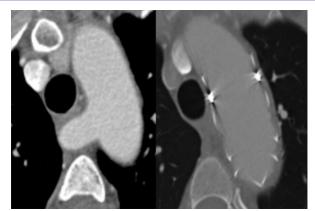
Comparison of pre-operative and post-TEVAR CTA showing successful repair.
